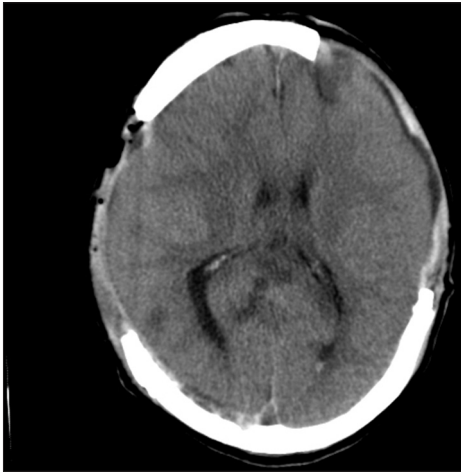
CT scan in a day after the EDH evacuation
